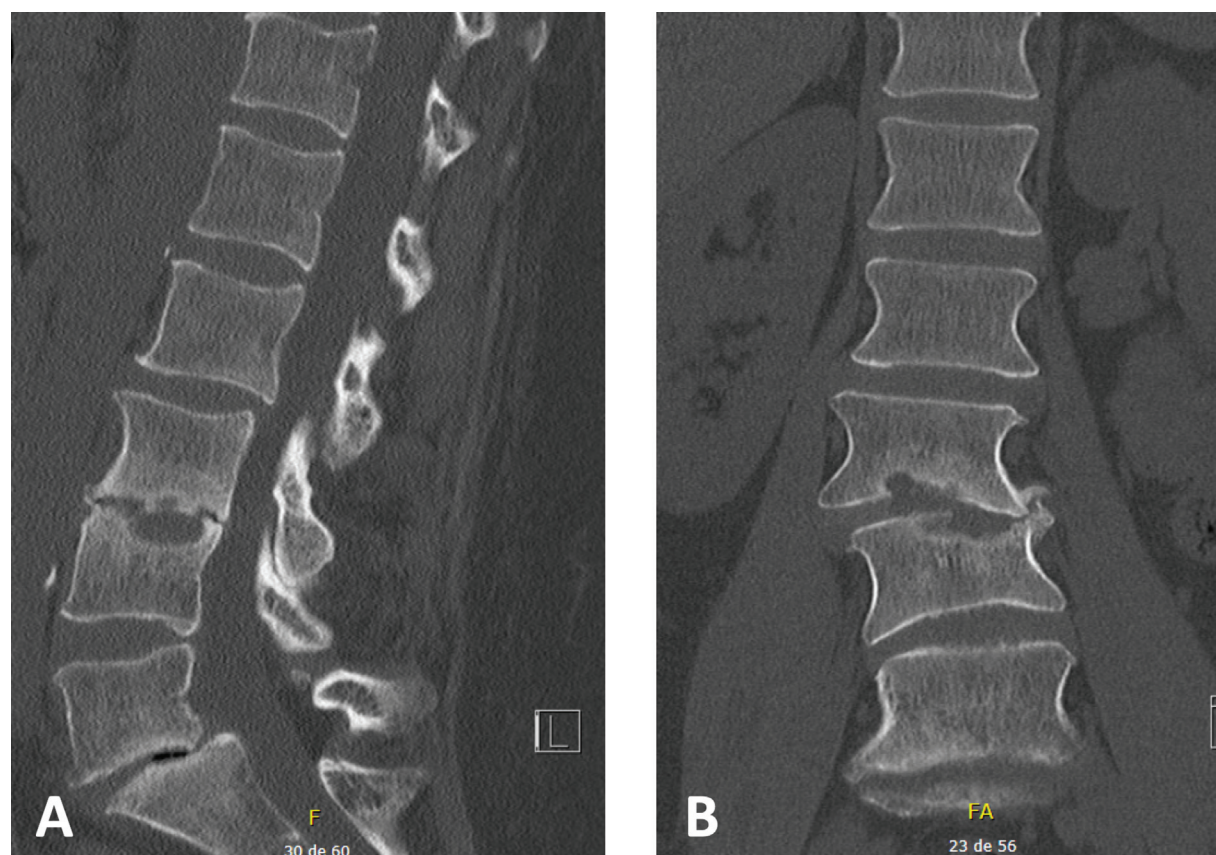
Computed tomography scan of the lumbar spine three months after the first hospitalization; (A) sagittal view; (B) coronal view.
